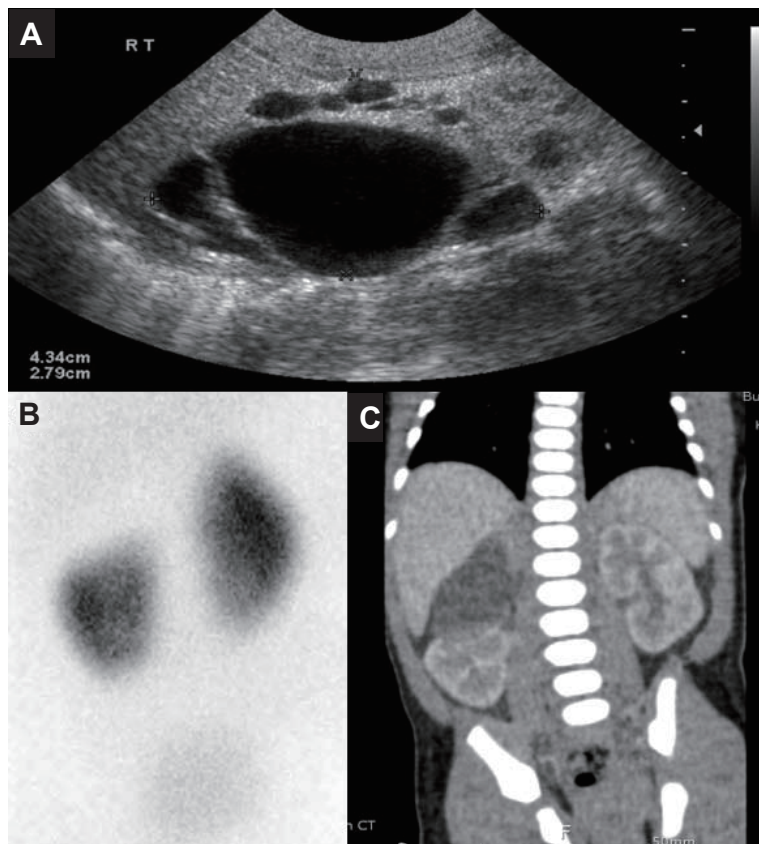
(A) Non-communicating multilocular cystic mass with small intervening hyperechoic solid portion on renal sonogram; (B) Small right kidney with suspicious cortical defect at the upper pole of the right kidney on 99mTc-dimercaptosuccinic acid renal scan; (C) Mainly cystic non-enhancing lesion at the upper portion of duplex right kidney on CT.
